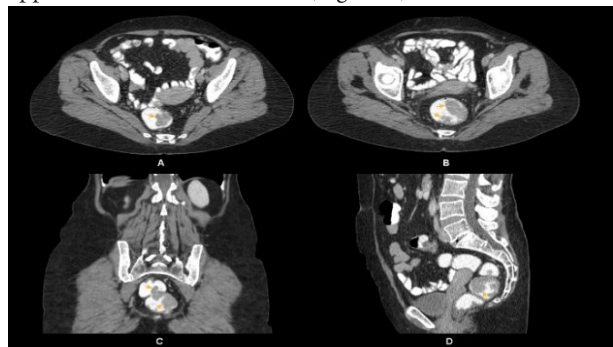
Intravenous and rectal contrast-enhanced Axial (A, B), sagittal (C), and coronal (D) computed tomography images demonstrate a polypoid mass lesion (arrows) originating from the posterior wall of the rectum, extending from the proximal anal canal to the rectum lumen, and generating an intraluminal filling defect
